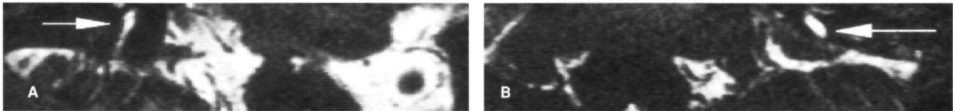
Patient A: Coronal reconstruction MRI through the endolymphatic ducts on the right (A) and left side (B). The left endolymphatic duct is abnormally wide, whereas the right one is of normal size (arrows). No endolymphatic sac could be visualized.
